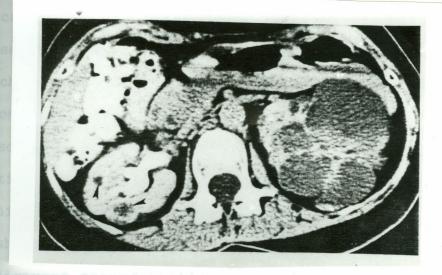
Adult polycystic kidney disease asymmetric involvement. Postcontrast CT scan demonstrates extensive cystic involvement of the left kidney. Small cysts are present in the right kidney (arrowheads). known diagnosis the search for focal neoplastic change or abcess often prompts C.T. evaluation. The cysts vary in size and are usually seen throughout the entire substance of the kidney. Most cysts are near water density. A symmetrical renal involvement such as the liver, the spleen, and the pancreas, can be evaluated similary. C.T. can detect the renal masses in familial polycystic kidney disease at a stage before renal enlargement or calyceal deformities. Also characteristic appearance can be seen even in the prescence of grossly impaired renal function. Ultrasound is the procedure of choice in the routine follow-up of patients with polycystic kidney disease and an initial screening of their family members. C.T. should be reserved for evaluation of possible haemorhage or malignment transformation.
